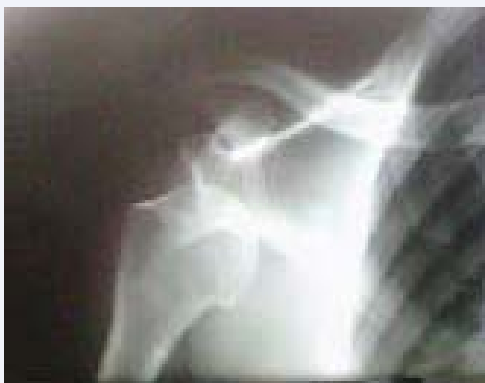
X-ray demonstrating subcoracoid glenohumeral dislocation.
